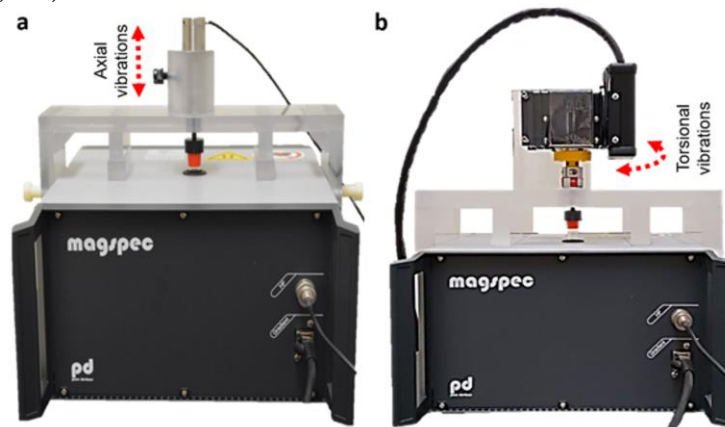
MRE setups mounted on tabletop MRI system by Pure Devices GmbH, Würzburg, Germany hosting piezoelectric actuator for axial MRE experiments (a) and stepper motor for torsional MRE experiments (b).
